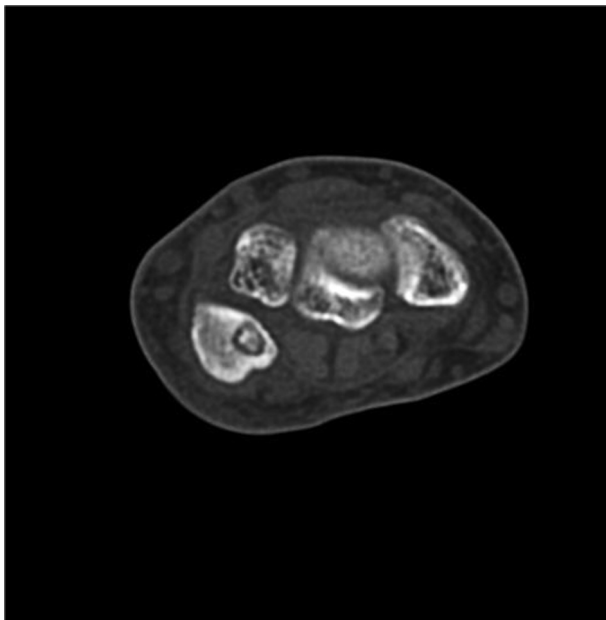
Transverse section of the pisiform in CT scan before the operation.
